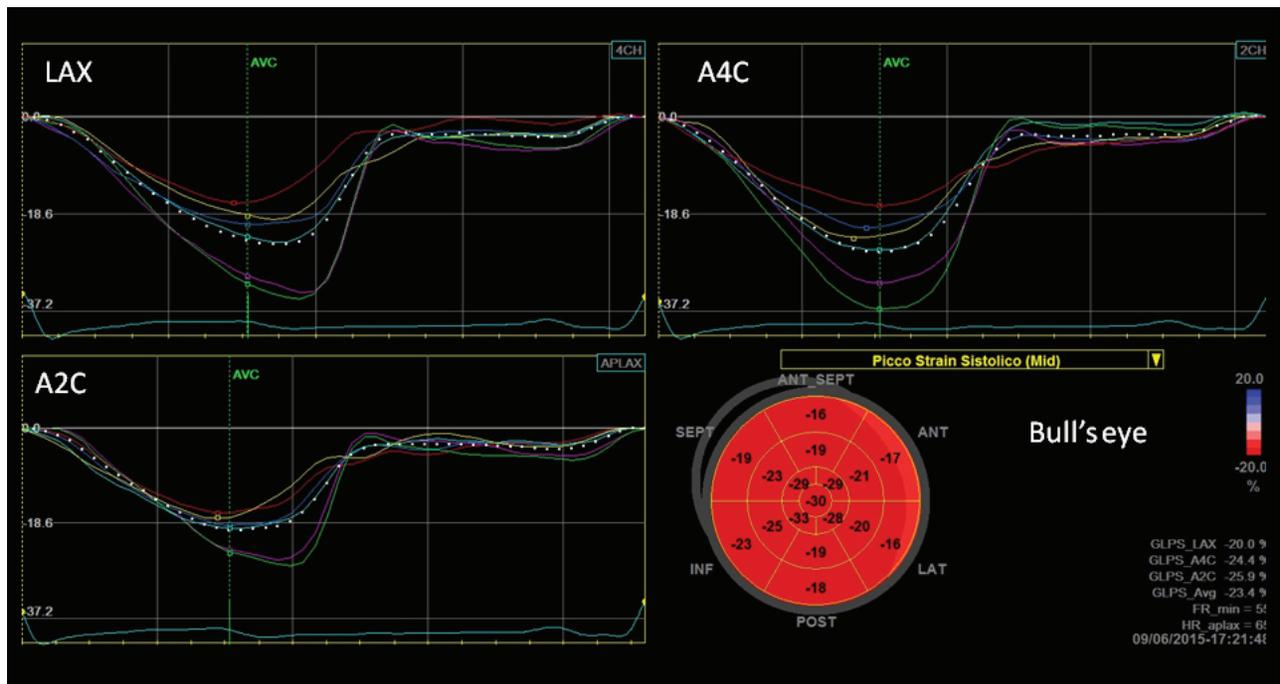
Automated function imaging (AFI) of left ventricular 2-D strain of endurance athlete, showing normal longitudinal regional myocardial deformation despite left ventricular hypertrophy (arrows) (LAX: long-axis view; A4C: apical four- and A2C apical two-chamber views). Bull's eye represents in a single image all myocardial regional deformations, from basal, to middle and apical segments.
